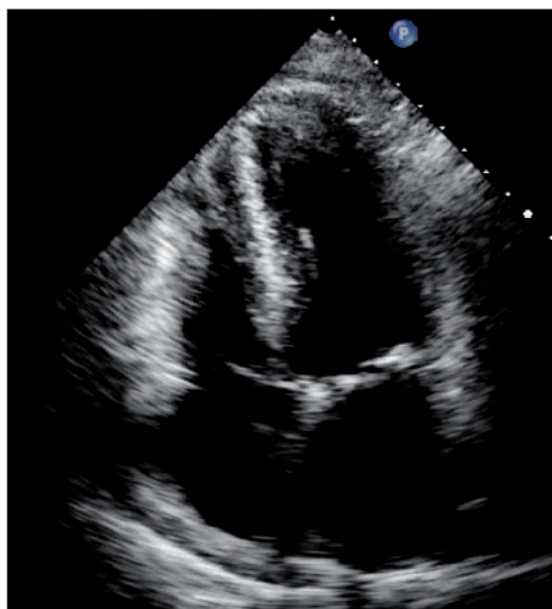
Transthoracic echocardiogram. Four chamber view still demonstrating normal left ventricular size and systolic function.
